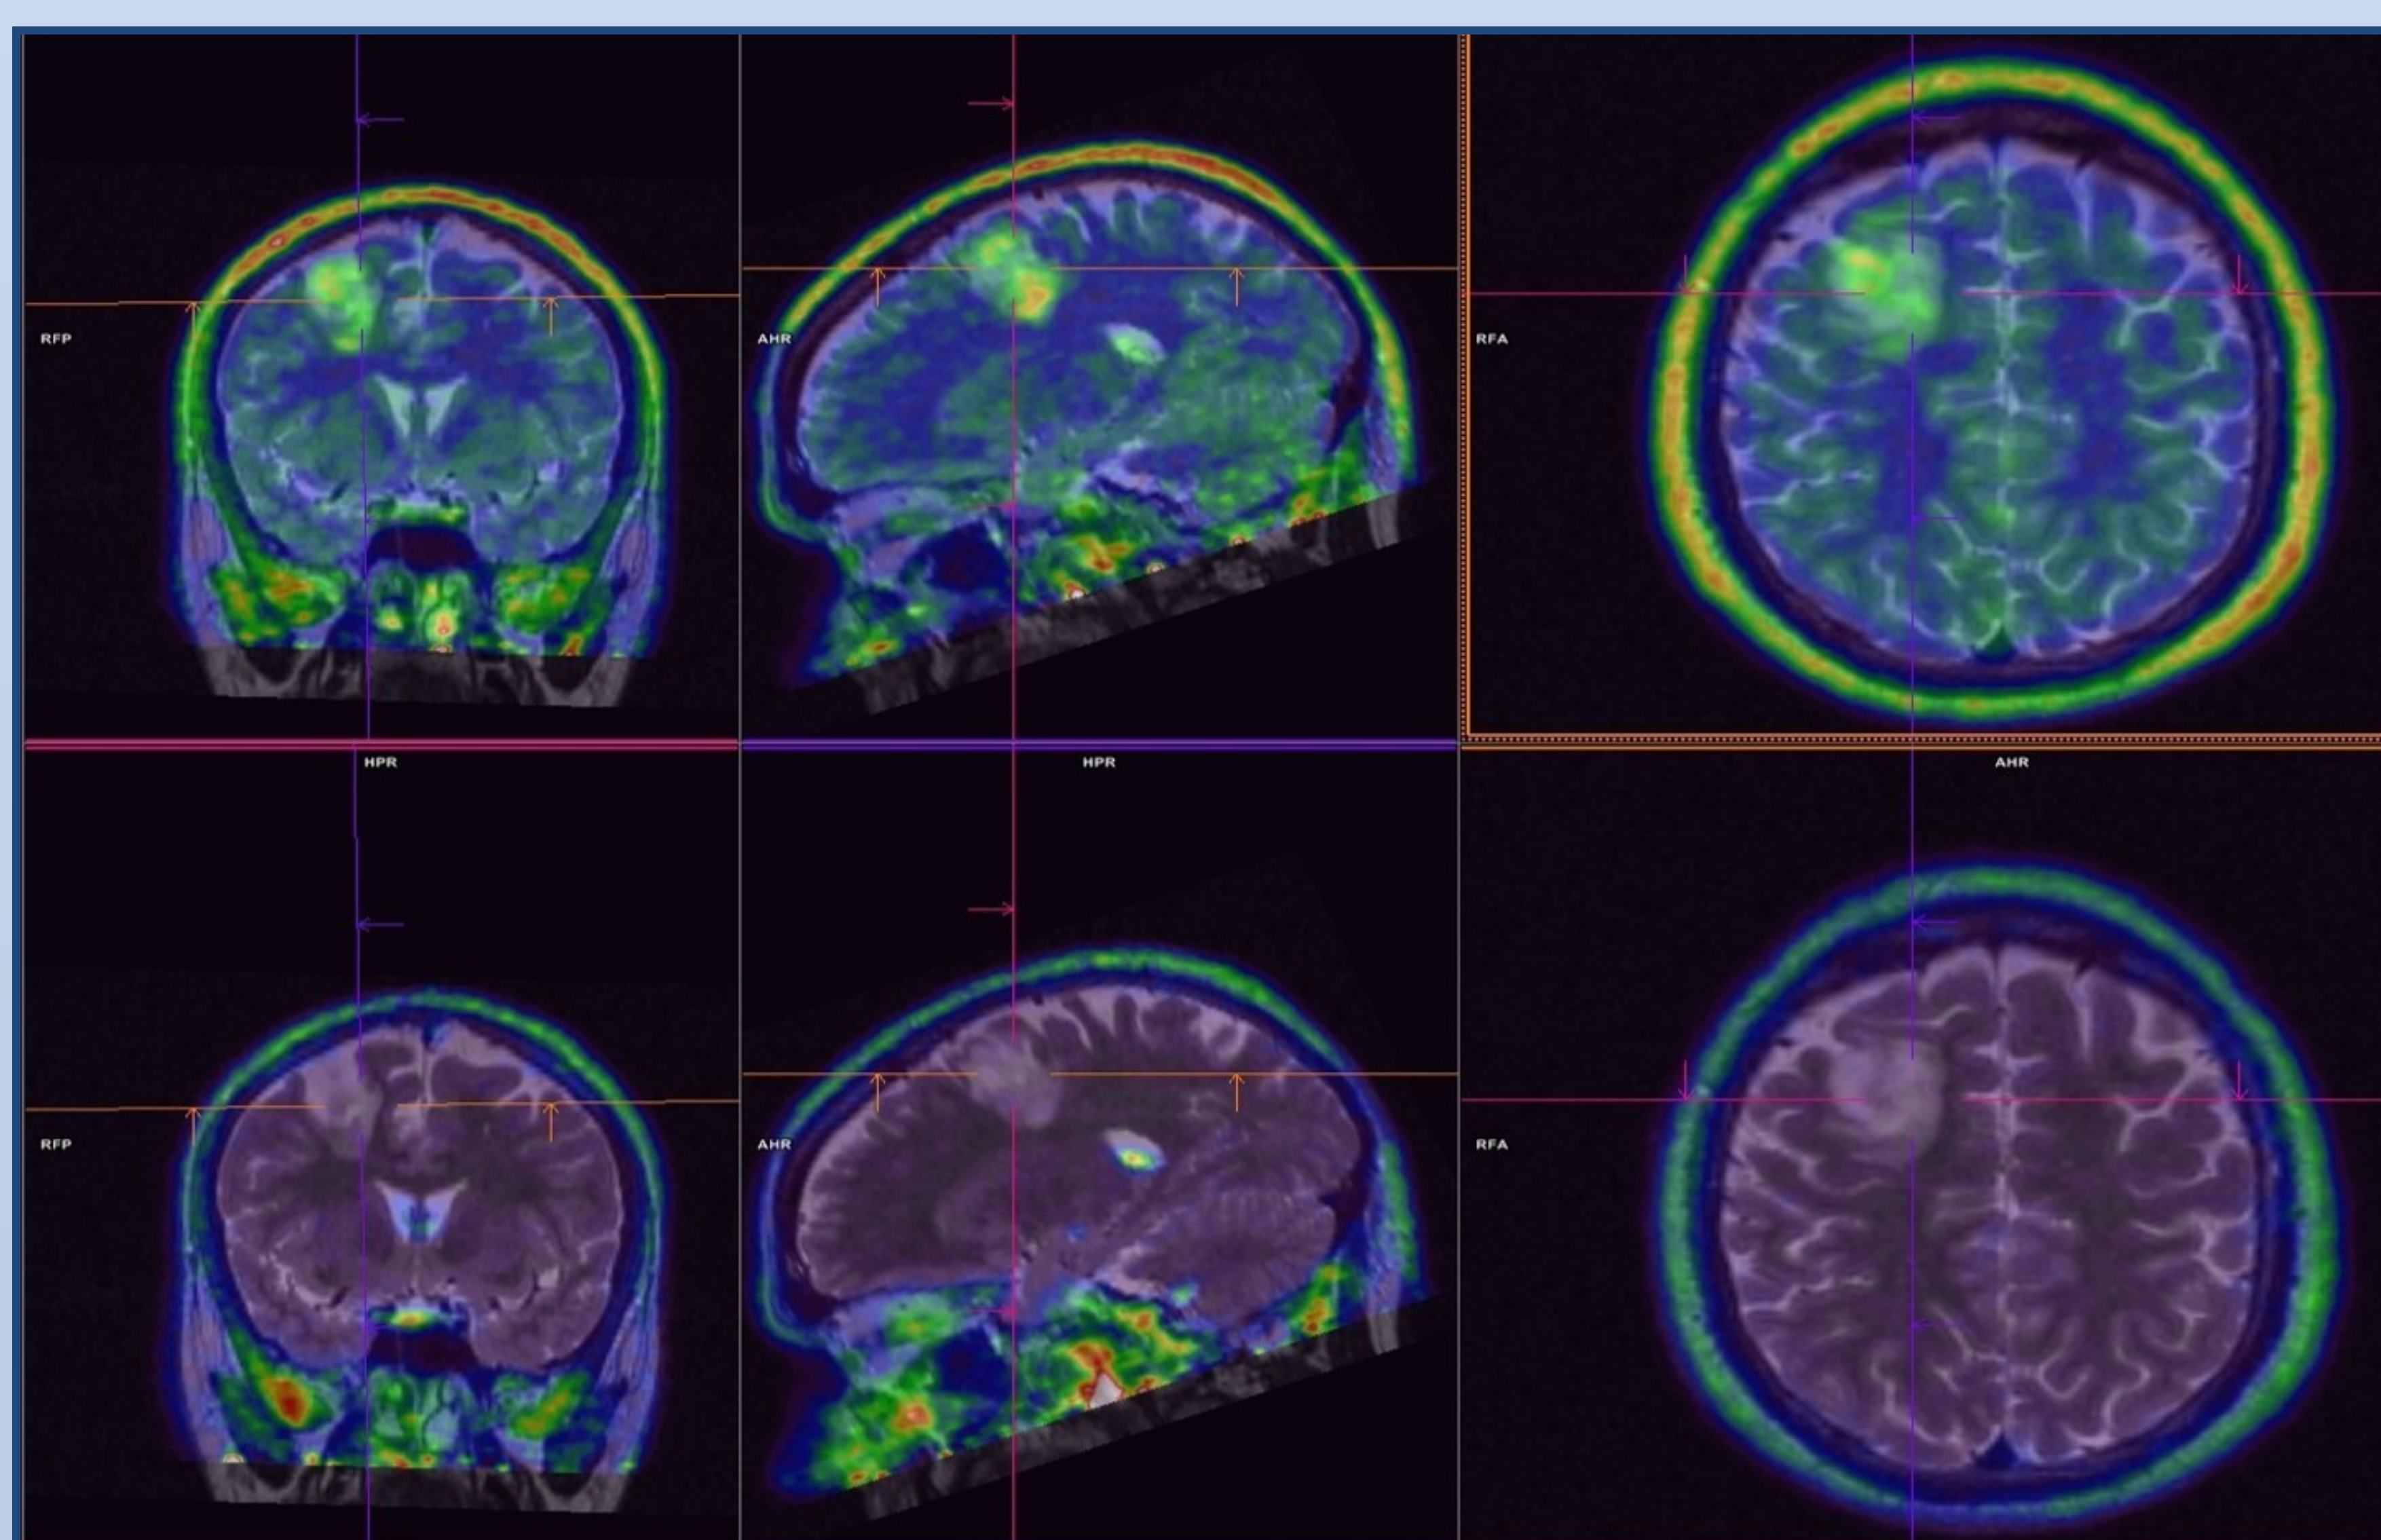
<sup>18</sup>F-FET positive PET fused with MRI (upper row), and <sup>18</sup>F-FCH negative PET fused with MRI (lower row) in a patient with LGG
